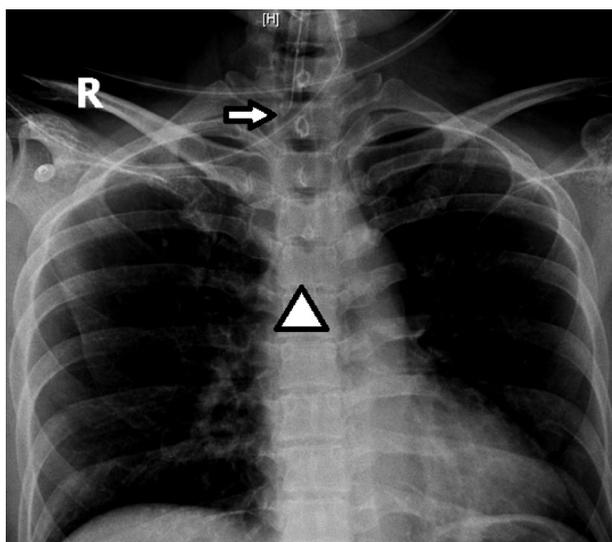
Postoperative chest radiography performed immediately after admission to the surgical intensive care unit. The arrow indicates the distal tip of the nasotracheal tube. The triangle indicates the carina
